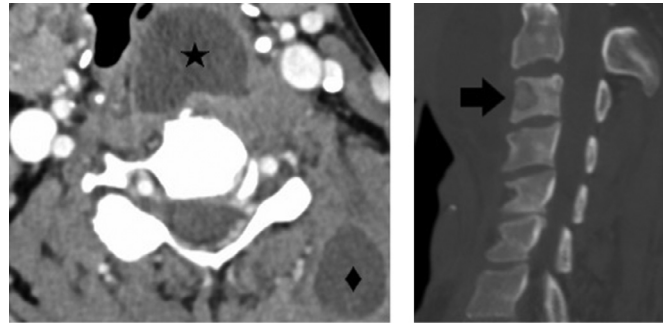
Axial post contrast CT image through the cervical spine at the C3 level in soft tissue window (Fig. 1A) demonstrates a soft tissue abscess anterior to the vertebral C3 vertebral body (star) and within the left paraspinal musculature (diamond). Sagittal CT image of the cervical spine in bone window (Fig. 1B) demonstrates a lytic region within the C3 vertebral body consistent with osteomyelitis. The disc space is preserved.
